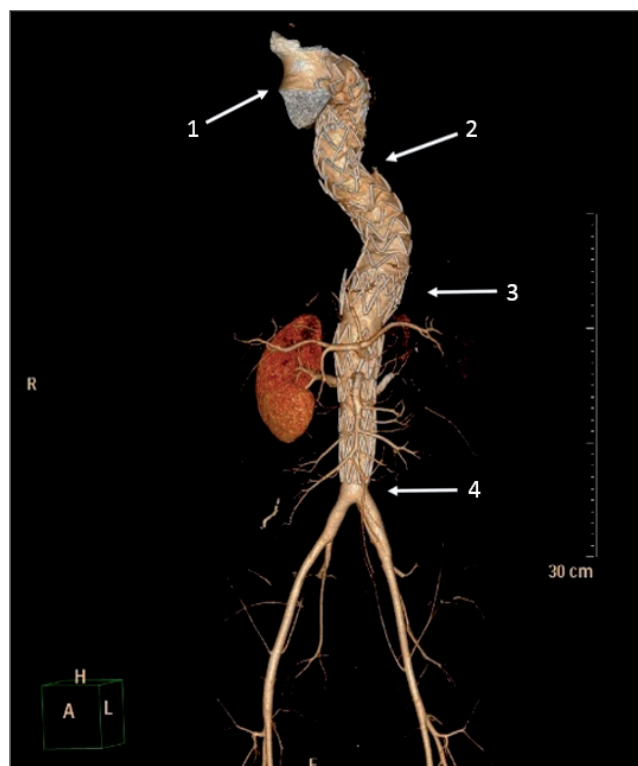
The most recent CT of the aorta, after consecutive endovascular and surgical interventions: 1 – Status post reimplantation of the aortic root and aortic valve replacement. 2 – Implanted stent-graft in the distal aortic arch, right after the ostium of the left common carotid artery. 3 – Two overlapping stent-grafts implanted in the thoracic aorta. 4 – Non covered dissection dedicated stent implanted in the thoracoabdominal aorta to the level of the bifurcation of the aorta, patent stents in the left renal artery and superior mesenteric artery, implanted through the cells of the aortic stent. No residual aortic dissection or aneurysm evident.
